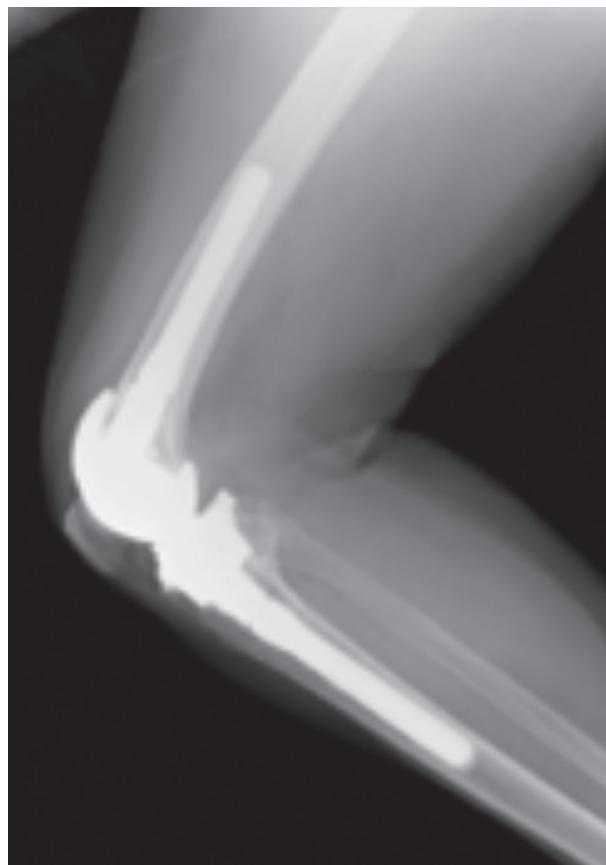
Case 3 – Post-operative lateral knee X-ray, showing evidence of callus formation 2 months post total knee arthroplasty.
